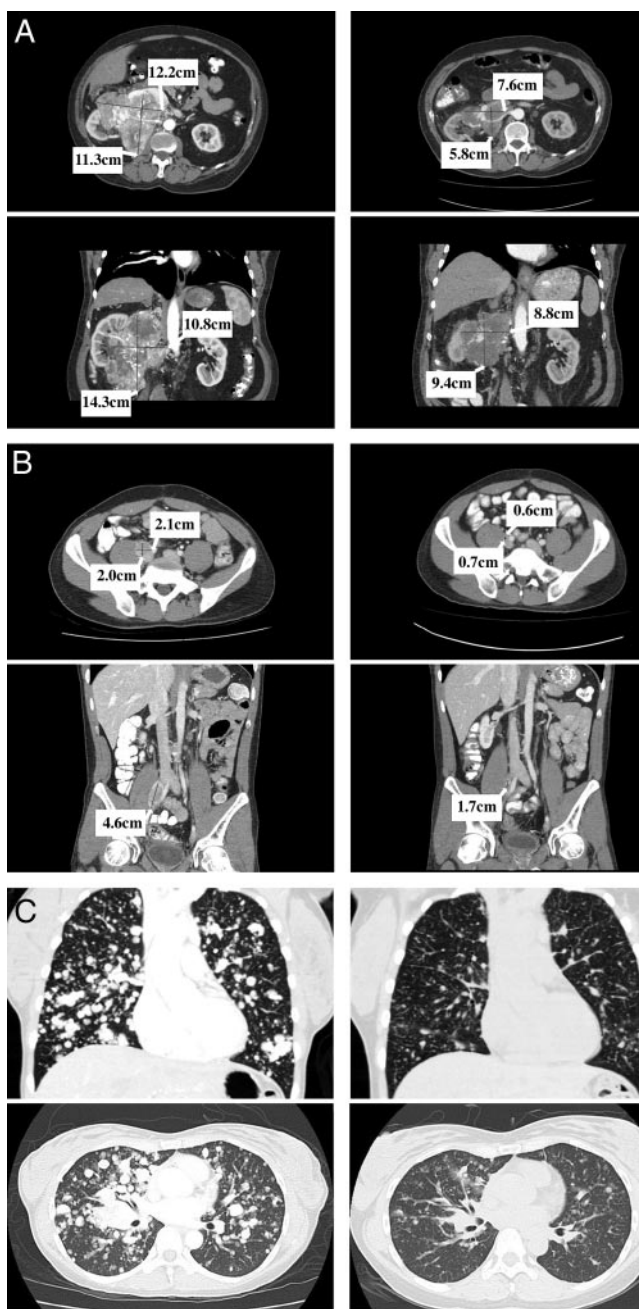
A, CT scans documenting responses to sunitinib in patient 1. Pre-treatment scan (left) demonstrating right renal pelvis mass in coronal (11.3 × 12.2 cm) and sagittal (10.8 × 14.3 cm) sections with post-treatment scans (right) demonstrating a significant reduction in size (5.8 cm × 7.6 cm and 8.8 cm × 9.4 cm respectively). B, CT scans documenting response to sunitinib in patient 2. Pre-treatment scan (left) demonstrating right pelvic lymph node in coronal (2.1 × 2 cm) and sagittal (4.6 cm) sections with post-treatment scans (right) demonstrating a significant reduction in size (0.7 × 0.6 cm and 1.7 cm respectively). C, Coronal and sagittal views of lung fields of patient 3 demonstrating a significant reduction in lung metastases.
